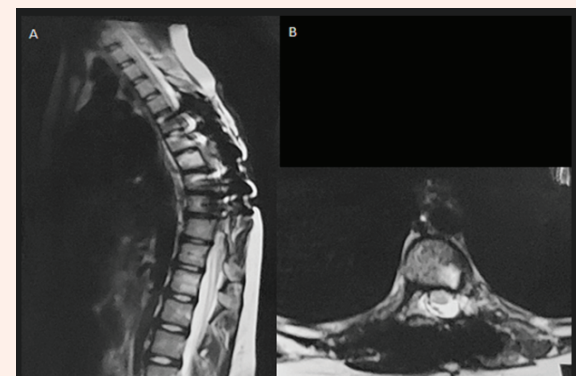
Control magnetic resonance imaging of the lumbar spine in T2 in midsagittal (A) and axial (B) sections at the level of the T8 vertebra showing regression of the lesion.
